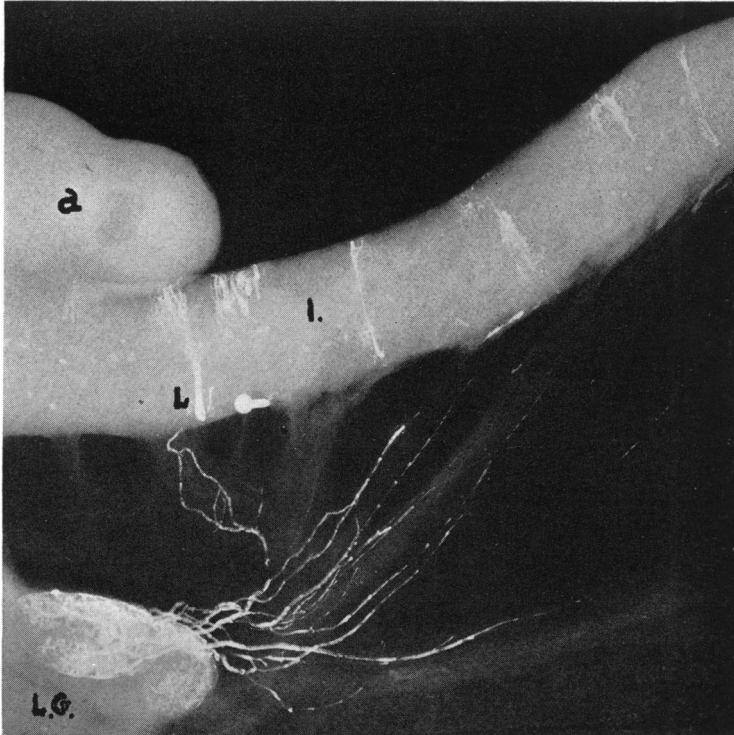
Roentgenogram of normal ileum and mesentery in which the lymphatics were injected directly with bismuth oxychloride (26 per cent) in an acute experiment. (a) Tip of appendix. (I) Ileum. (L.G.) Regional lymph node filled partially with bismuth from mesenteric lymphatic and subserosal lymphatic injections. (L) Lacteal filled from subserosal injection.
